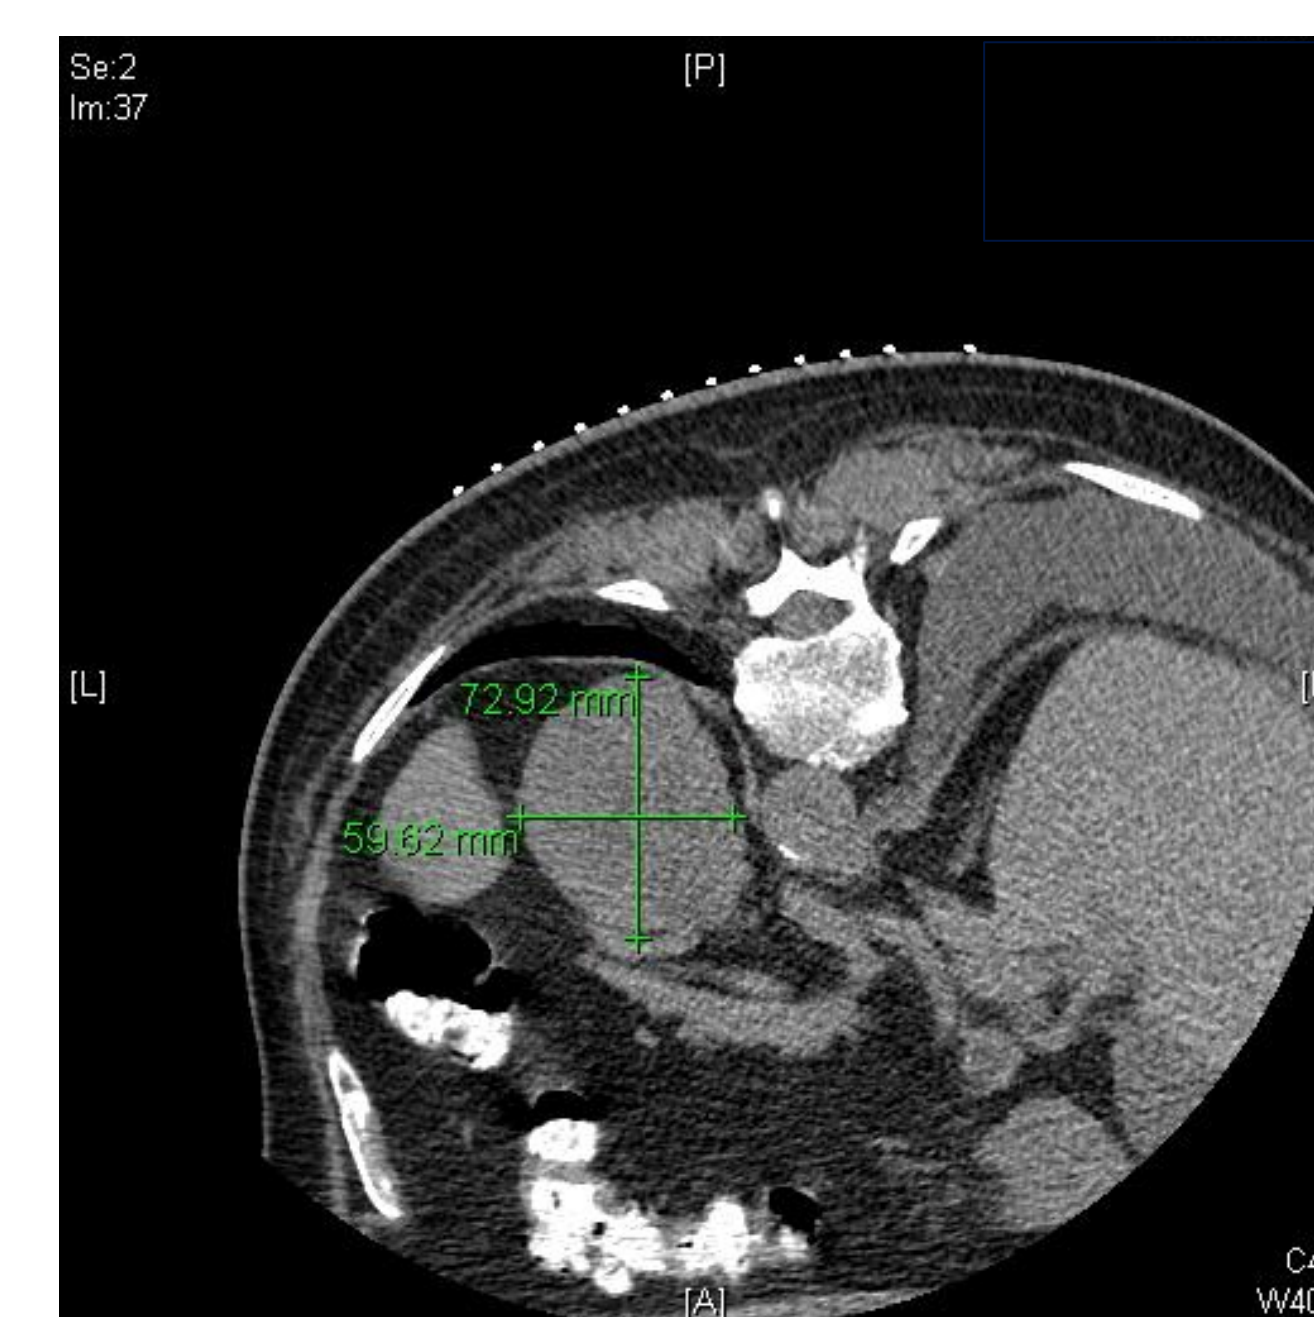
Transverse view of the adrenal mass during a prone, CT-guided adrenal biopsy
